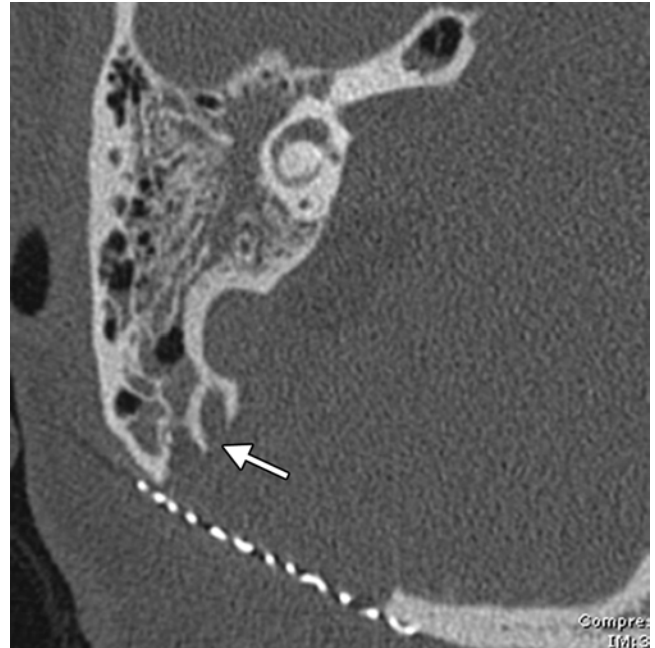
Mastoid entry with CSF leakage. The patient presented with right CSF otorrhea after surgery. Axial CT image showing a right retrosigmoid cranioplasty and entry into the posterior mastoid air cells (arrow). The mastoid air cells and antrum are partially opacified.
